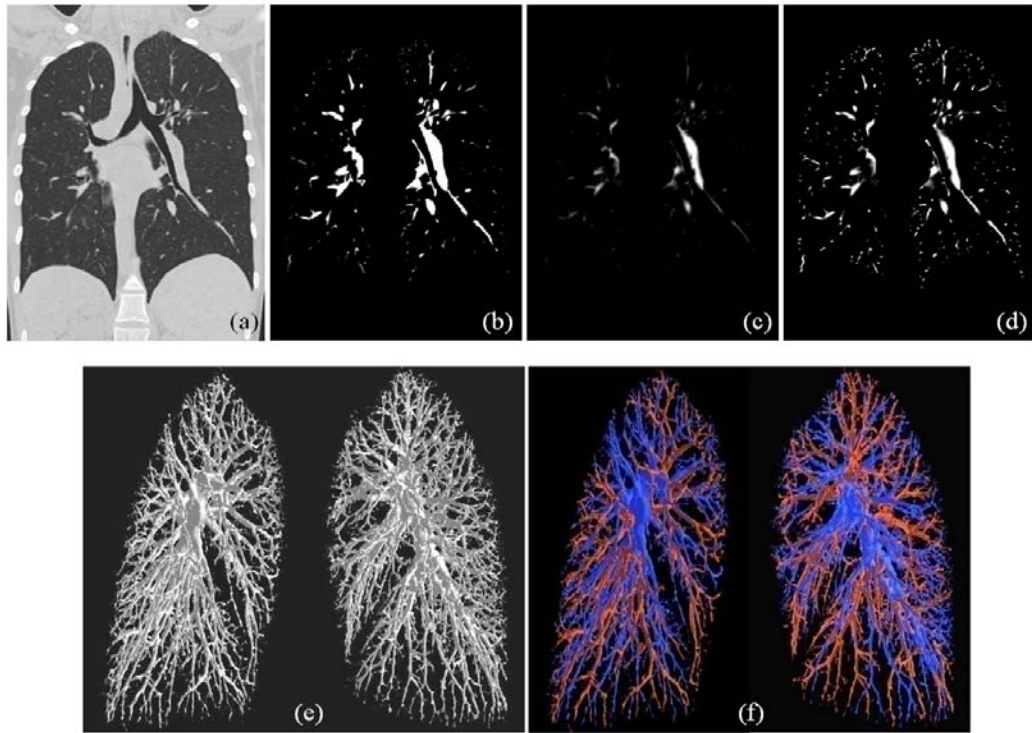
Results of application of the method to a human in-vivo pulmonary CT image. (a) A coronal image slice from a thoracic CT image of a 22 years old female. (b) Fuzzy segmentation of vasculature. (c,d) Original (c) and local-scale normalized (d) FDT maps of the vasculature. (e) 3D surface rendition of left and right pulmonary vascular trees. (f) A color-coded 3D rendition of separated arterial and venous trees computed by the proposed method.
